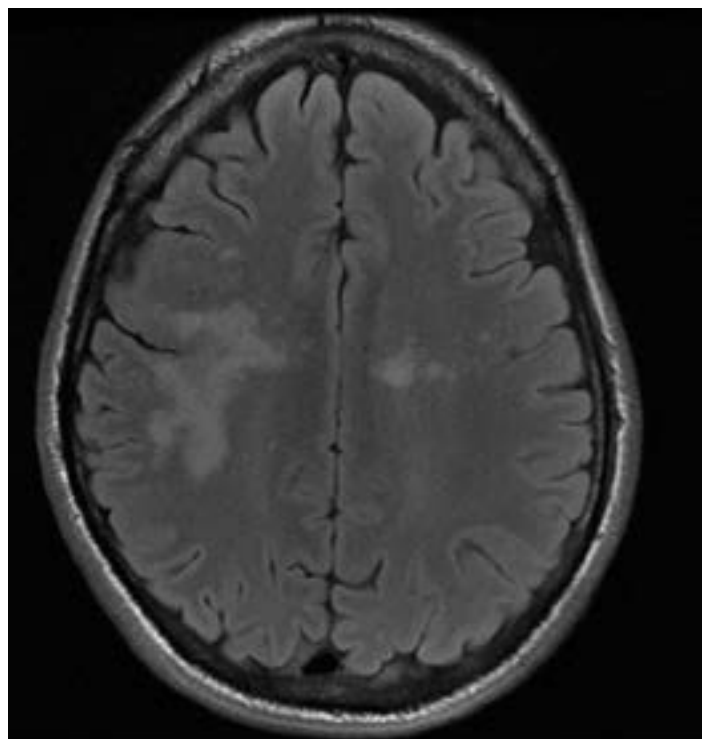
Initial Brain MRI findings suggestive of progressive multifocal leukoencephalopathy in the right frontoparietal white matter and right thalamus with possible other foci of disease in the left corona radiata.
